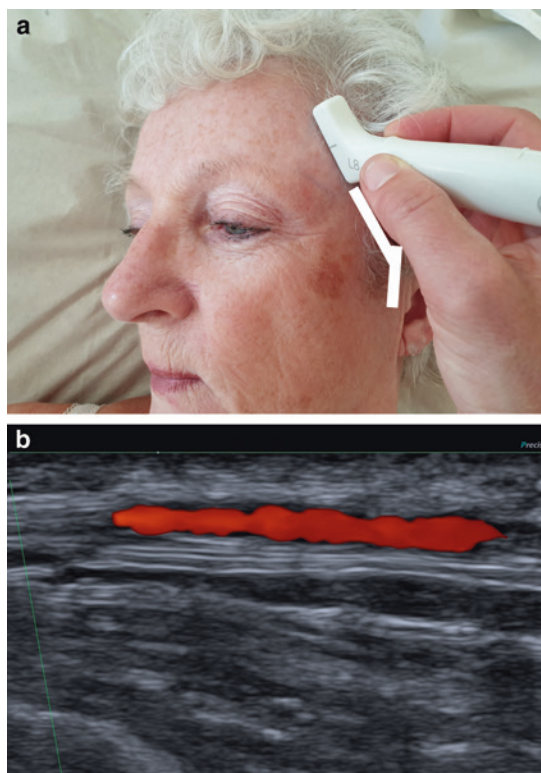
Examination of the frontal temporal artery: a recommended position of the transducer b ultrasound image, longitudinal view
